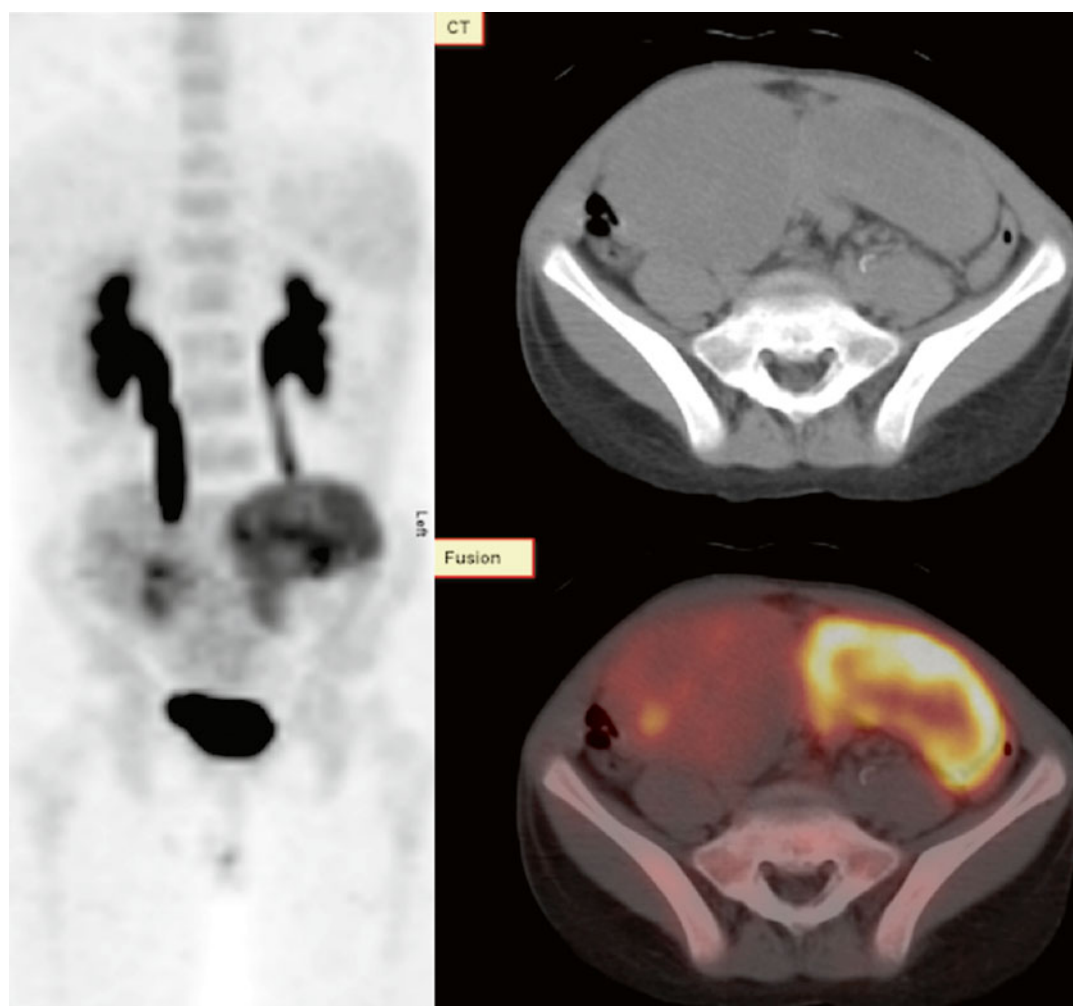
A 9-year-old female with pelvic masses. Fluorine-18-FDG PET/CT (*left* MIP; *right upper row* low dose CT; *lower* co-registered PET/CT axial views) confirmed 2 solid pelvic masses with variable FDG uptake
